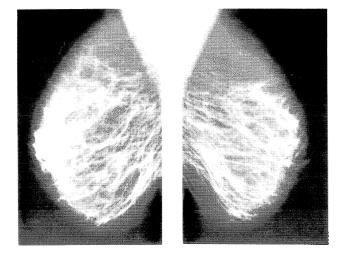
2c*. Mammogram of anterio-posterior radiograph, b right breast, c left breast.
